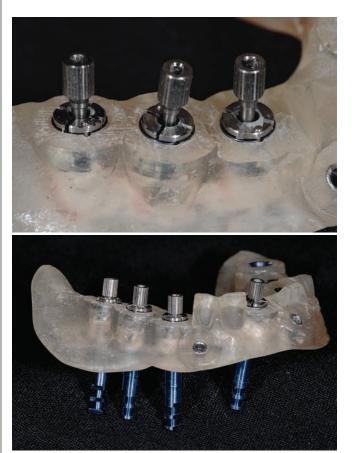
R and S, These two views show the analogs attached to a special prosthetic part that locks the analog to the guide sleeve of the surgical guide stent. The master cast will then be modified to allow for seating of the implant analogs based on their planned virtual positioning, resulting in a master cast with the implant analogs very close to the position that they will placed by using CT-guided surgery.
